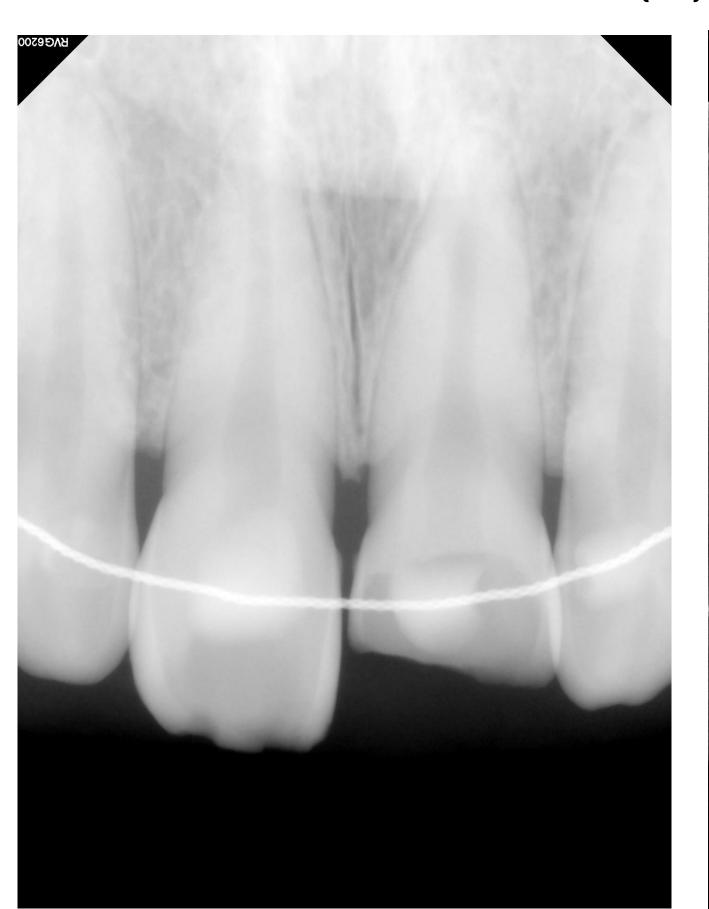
4B. Periapical x-ray (A) pre-OP (B) post-OP
